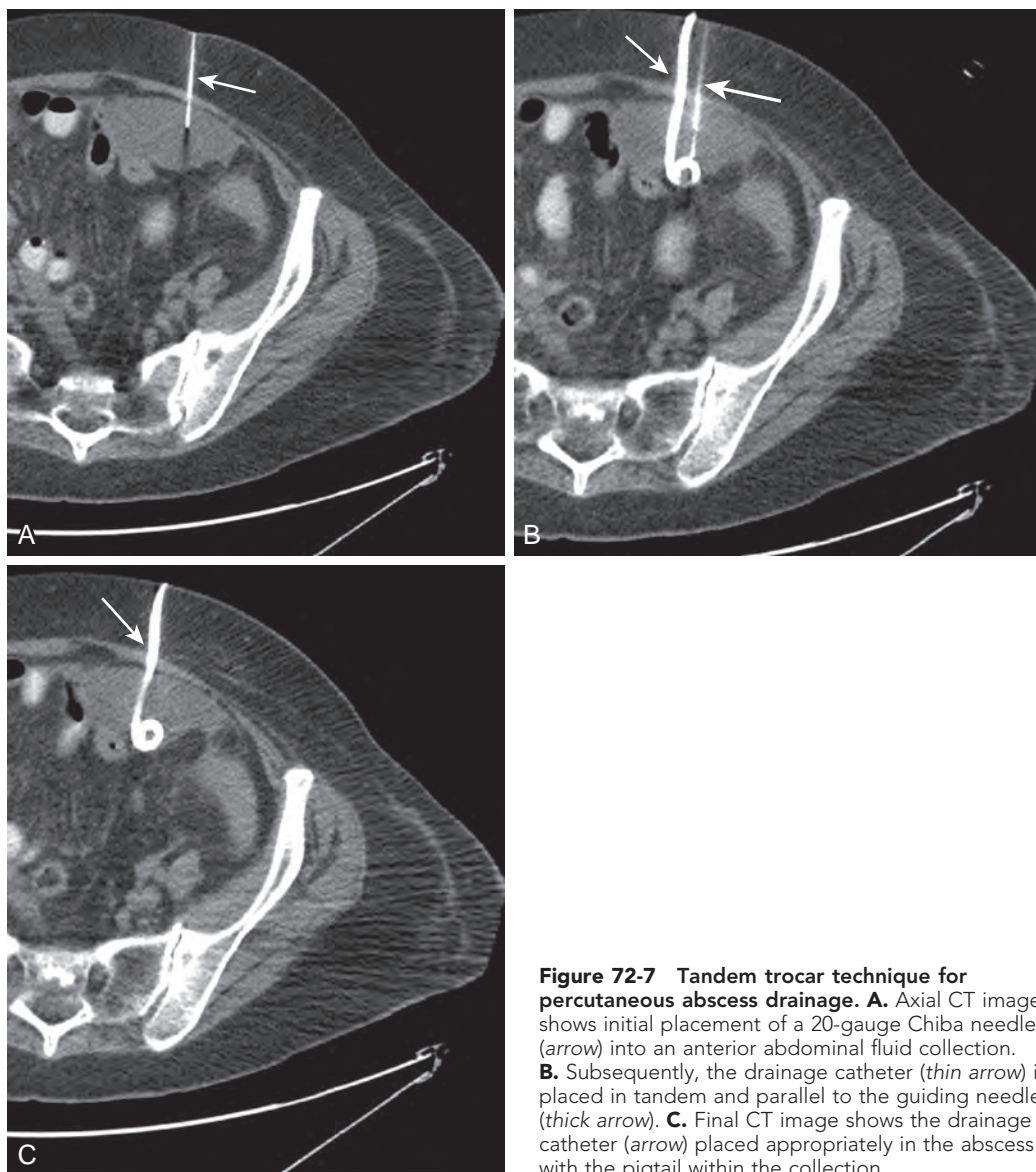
Tandem trocar technique for percutaneous abscess drainage. A. Axial CT image shows initial placement of a 20-gauge Chiba needle (arrow) into an anterior abdominal fluid collection. B. Subsequently, the drainage catheter (thin arrow) is placed in tandem and parallel to the guiding needle (thick arrow). C. Final CT image shows the drainage catheter (arrow) placed appropriately in the abscess with the pigtail within the collection.
